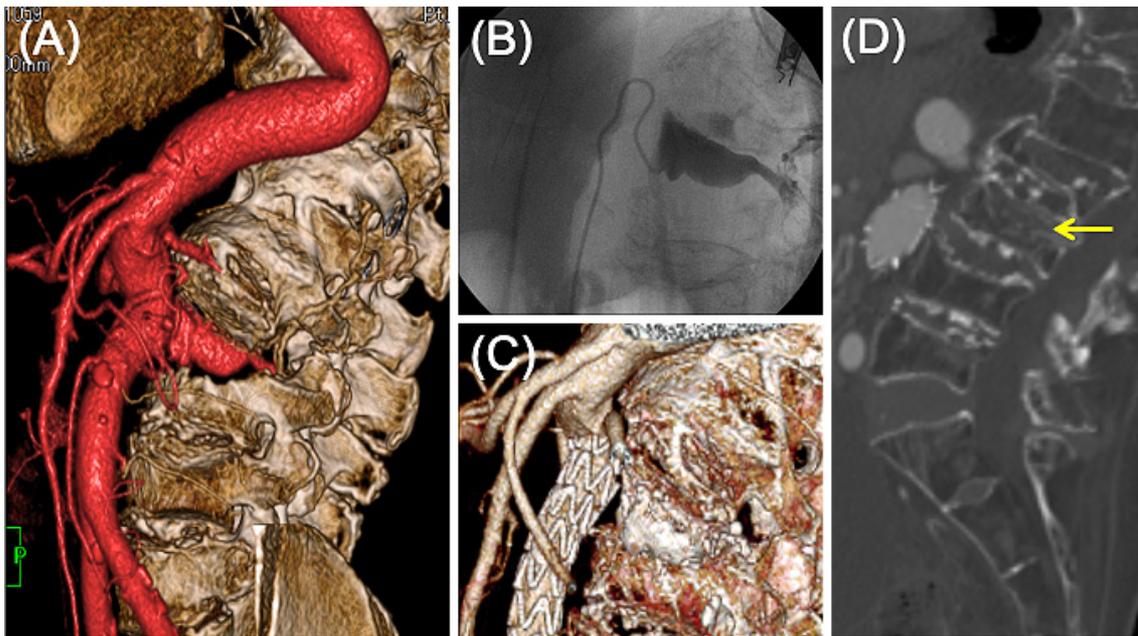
(A) Contrast-enhanced CT showed the aneurysm originated from the aorta located within the pre-existing L3 vertebral body, with no apparent contrast leakage. (B) The pseudoaneurysm’s shape matched the fractured L3 vertebral body. The left L3 segmental artery supplied the blood that formed the arteriovenous fistula with perivertebral veins. (C) An intravascular stent in the abdominal aorta. (D) The patient’s evaluation showed stable bone fusion of the L3 vertebral body one year after the injury (Arrow).
